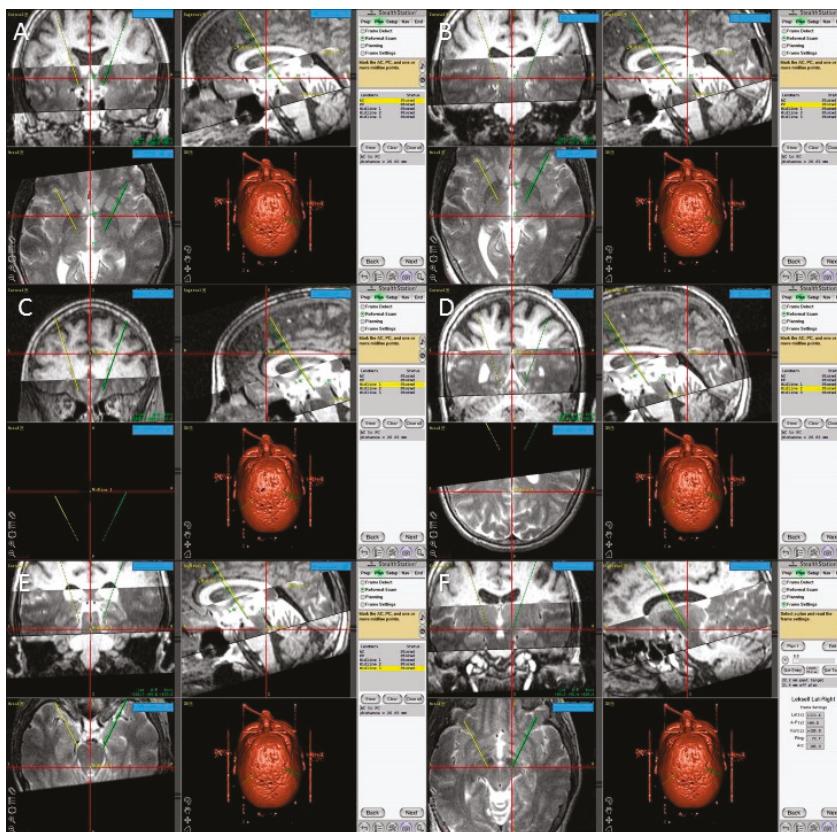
Screen shots from the FrameLink software of the StealthStation showing fused T1 and T2 magnetic resonance imaging (MRI) images of the patient and the planning process with identification of the posterior edge of the anterior commissure (A); the anterior edge of the posterior commissure PC (B); three midline points (C–E); and the final coordinates of the right subthalamic nucleus (F).
